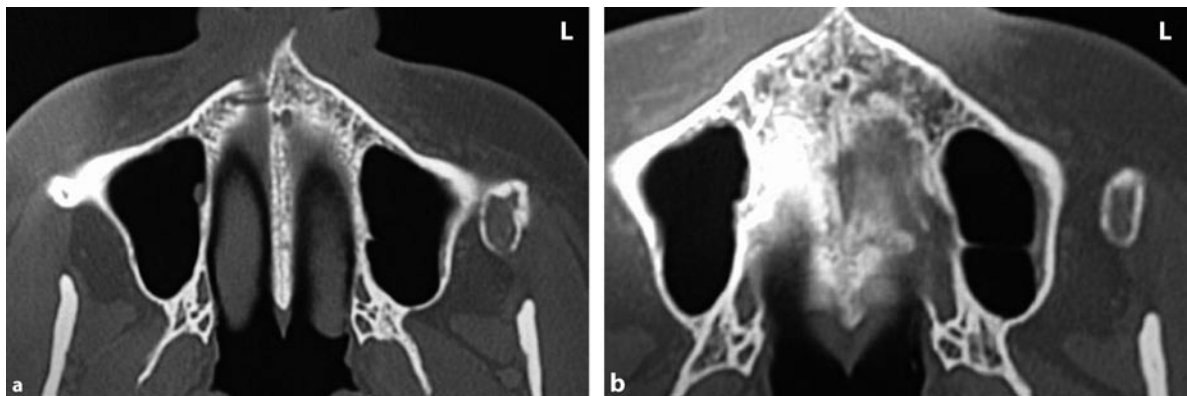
Computed tomography scans at initial presentation (a,b). Axial sections of the maxillary sinus and zygoma shows the bony surplus in the left infratemporal fossa anterior to the ascending ramus. c–h see next page
